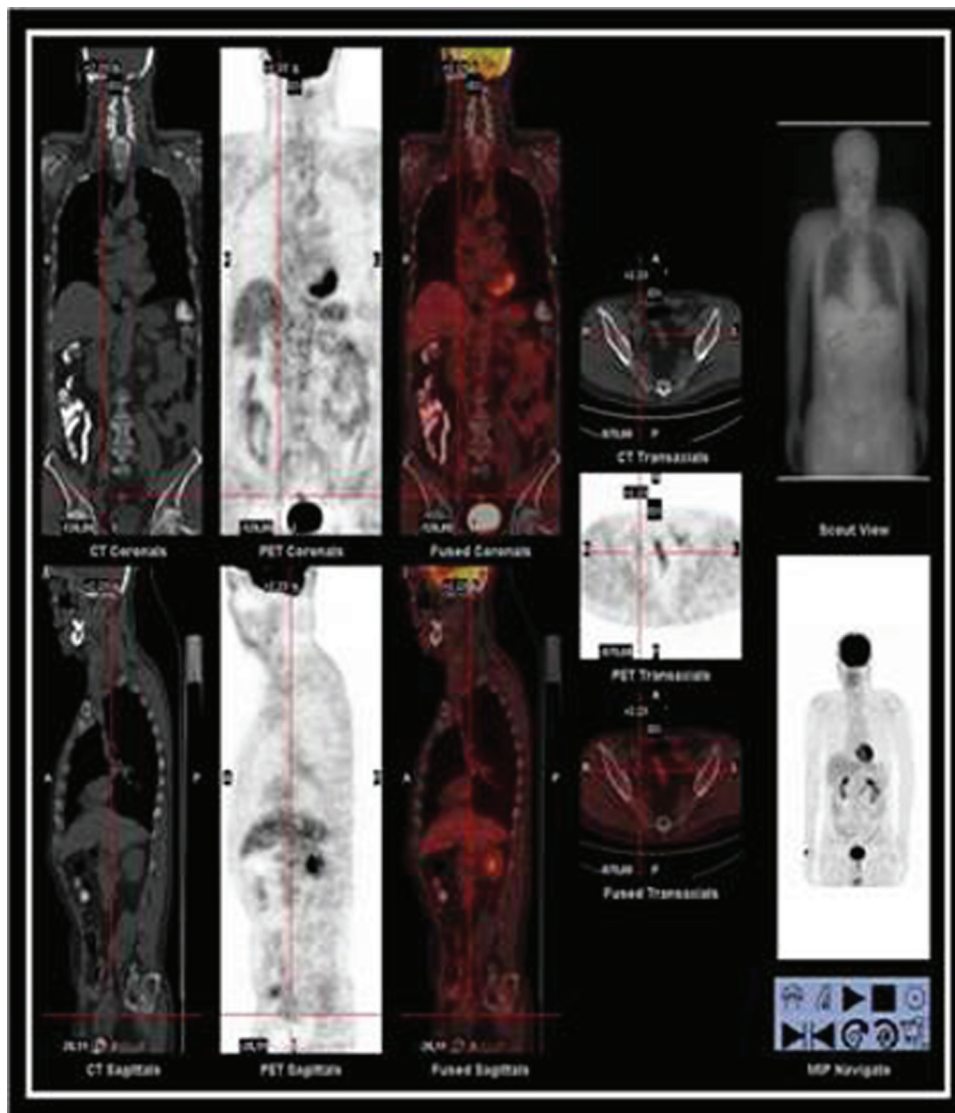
Whole body coronal, sagittal, transaxial PET, CT and fusion images and maximum intensity projection images.
